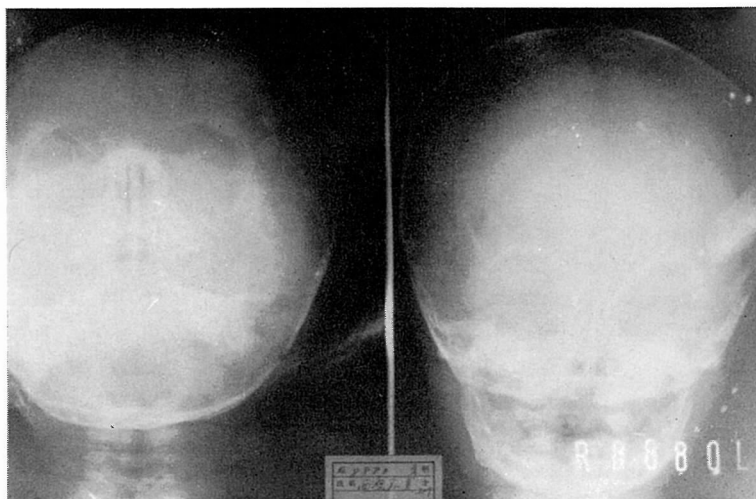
X-ray of the nose.
